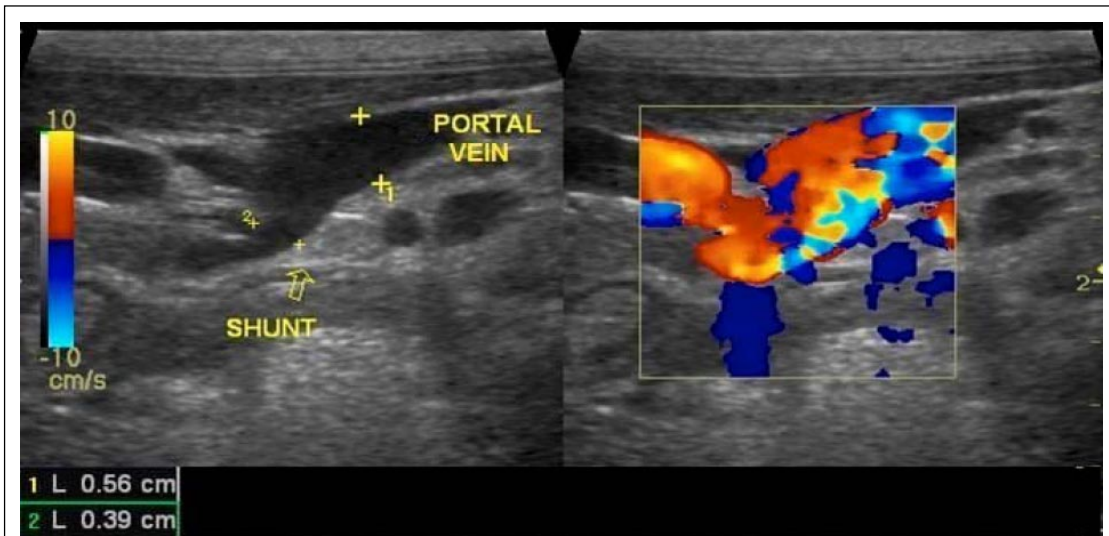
Color Doppler ultrasonography showing shunting vessel with turbulent blood flow between portal vein and caudal vena cava.
